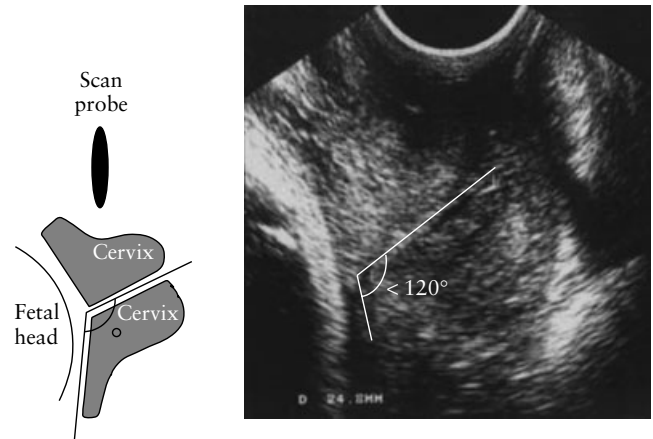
Reference points for measuring posterior cervical angle and ultrasound picture demonstrating this measurement.
